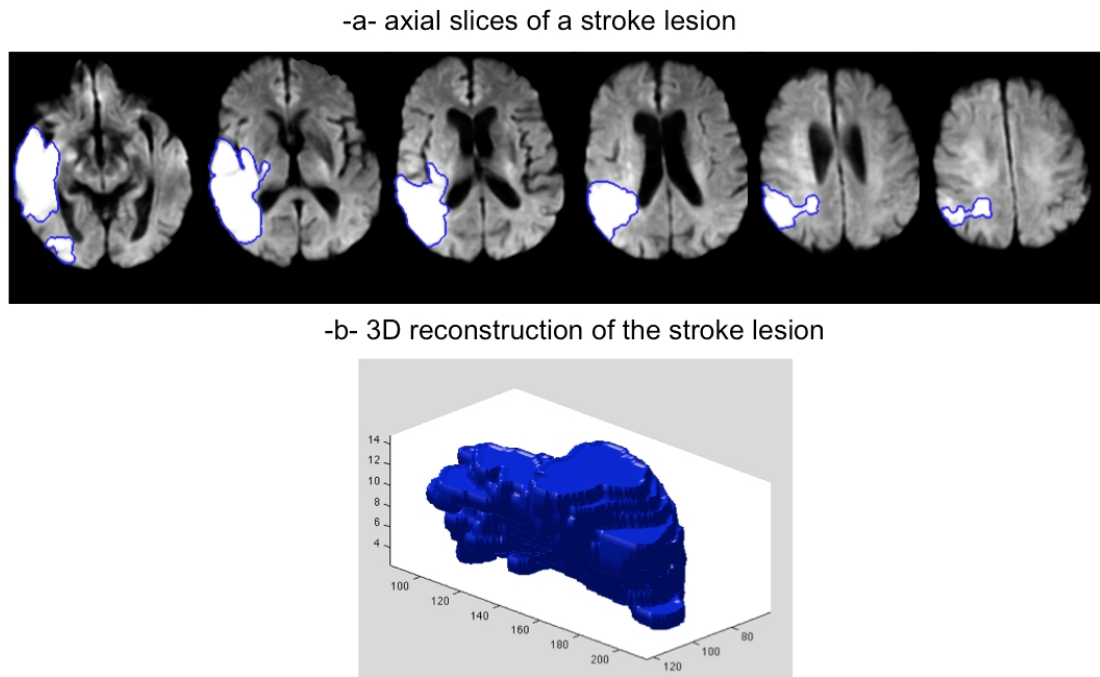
Visualizing a stroke lesion as a 3D surface.* (a) Multiple DWI axial slices showing the bright stroke lesion manually outlined in blue. (b) A 3D reconstruction of the stroke lesion. More geometric information can be retrieved from representing the stroke lesion as a 3D surface construction such as curvature and normal/tangent vectors.
